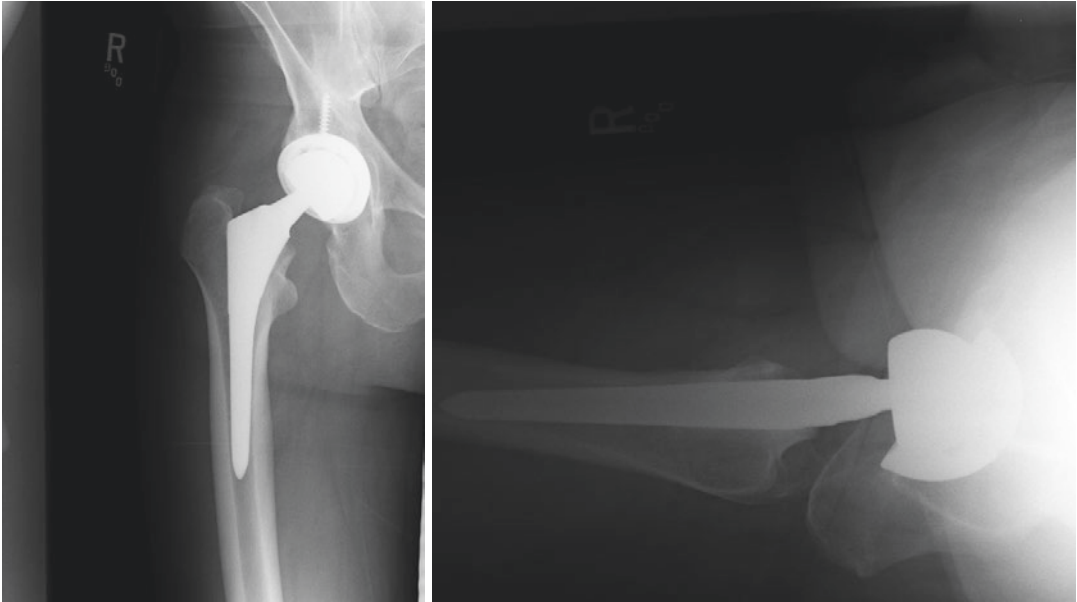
AP (anteroposterior) and cross-table lateral radiographs showing undersized stem in varus and flexion
